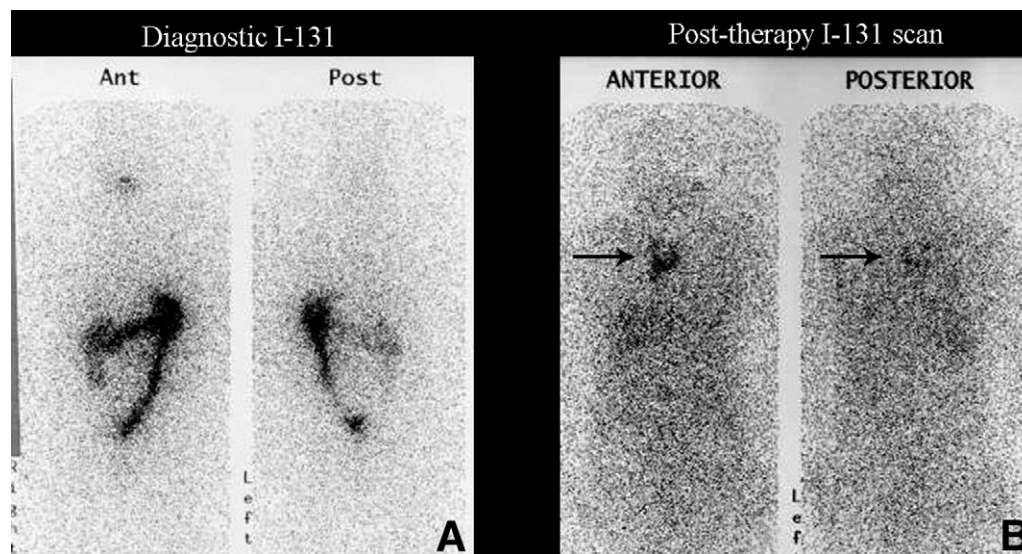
(A) Anterior and posterior whole body images from I-131 scans obtained 12 weeks after thyroidectomy for papillary thyroid carcinoma in a 15-year-old patient reveal no evidence of residual or recurrent disease. (B) Whole body scan obtained 10 days after I-131 therapy (with a empiric dose of 150 mCi (5.6 GBq) of I-131 adjusted for patient weight/body surface area) shows uptake in the thymus and in the liver. CT scan (not shown) identified the presence of a small residual thymic gland and confirmed the absence of mediastinal disease. Diffuse liver uptake, commonly seen on post-therapy scans, should not be mistaken for metastatic disease unless more focal uptake is present.
